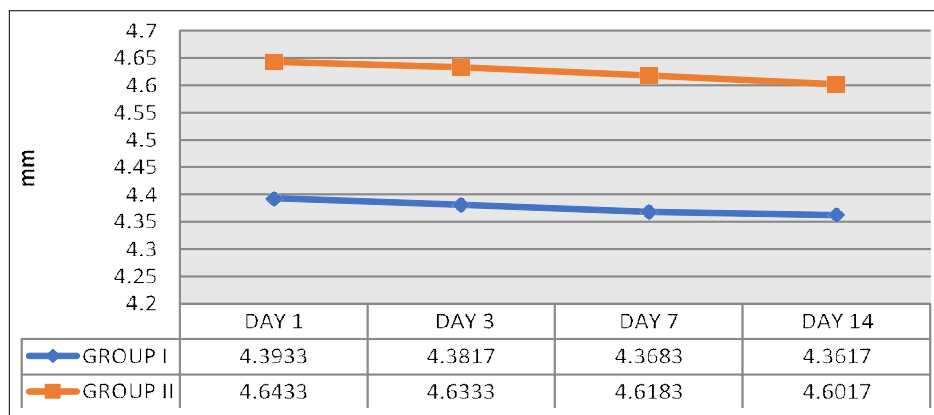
Urethral lumen diameter radiographic assessment.
